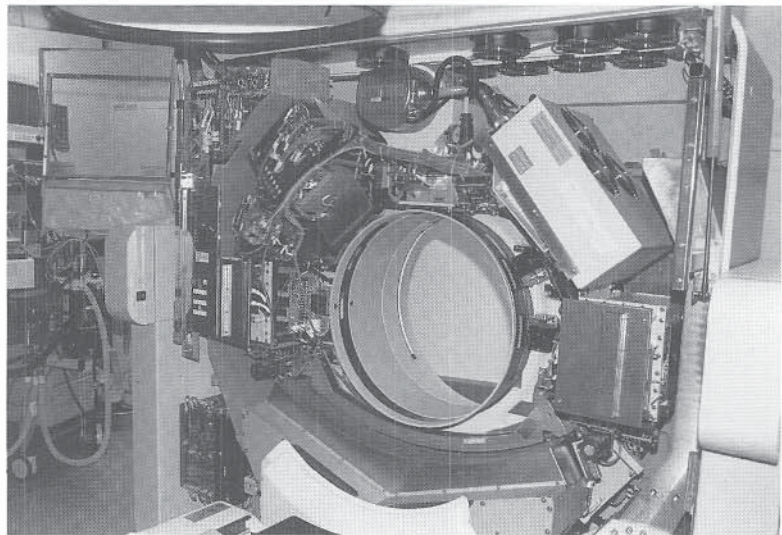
The covering of the CT scanner has been removed to show the x-ray tube mounted on its slip ring and other internal components of the scanning gantry. Slip ring technology allows the continuous tube rotation that is needed in volume scanning.
